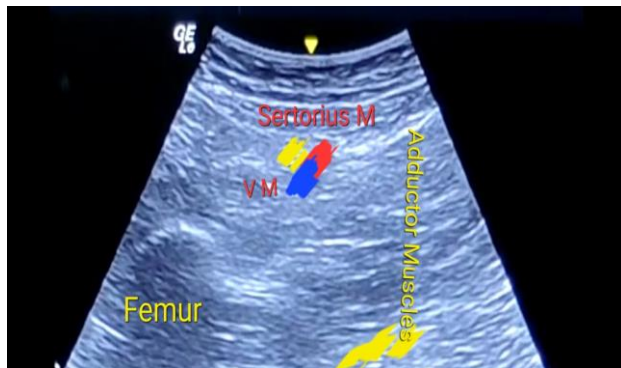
Ultrasonographic image showing the neurovascular bundle, bony and muscular anatomical landmarks for performing the anterior sciatic and adductor canal blocks
